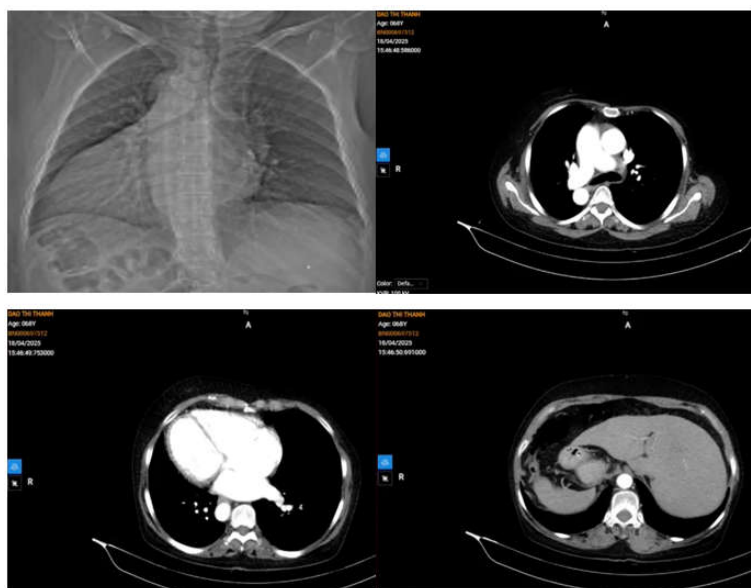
Chest X-ray and Thoracic computed tomography (CT) confirming situs inversus totalis
